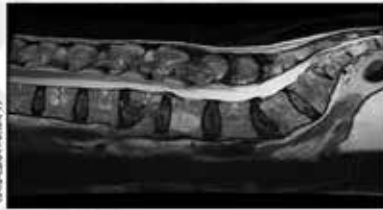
MRI demonstrating moderate to severe spondylolisthesis fracture at T2 with large soft tissue and left paravertebral extension tumor as well as a mild spondylolisthesis fracture at L5.
